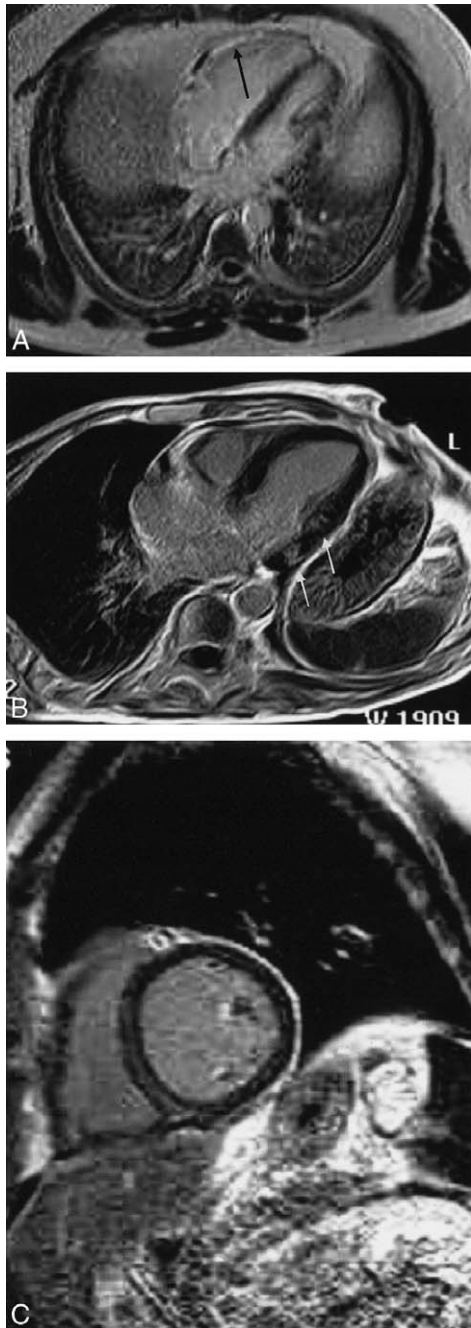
Different patterns of late enhancement. (A) TFE-inversion recovery T1-weighted images shows late-enhancement stria in right ventricular free wall (arrow) in a patient with active myocarditis involving both ventricles. (B) Contrast-enhanced cardiac magnetic resonance showing late-enhancement foci in the lateral wall in active myocarditis. (C) TFE-inversion recovery T1-weighted images showing a mid-wall late-enhancement stria located in the medial interventricular septum in a patient with heart failure and borderline myocarditis.
